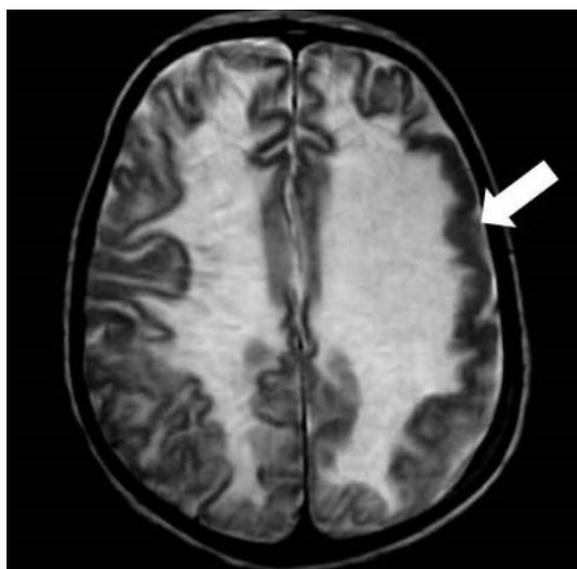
3-year-old female with vanishing white matter disease. Axial T2 weighted MR image shows a type 2 pattern polymicrogyria in left cerebral hemisphere (arrow).
